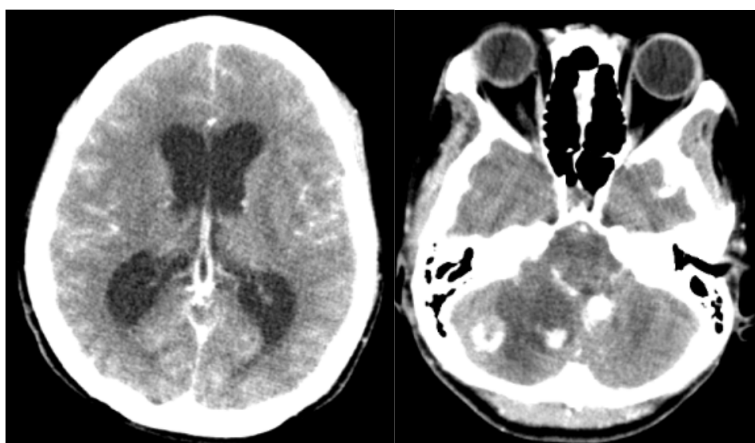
Brain tumor of cerebellum. Patient, F/27, with convulsion and loss of consciousness. Post-contrast CT of the brain shows obstructive hydrocephalus of ventricles due to posterior fossa tumor (left), and multiple cystic tumors with enhancing nodules in the cerebellum, hemangioblastomas most likely (right).
